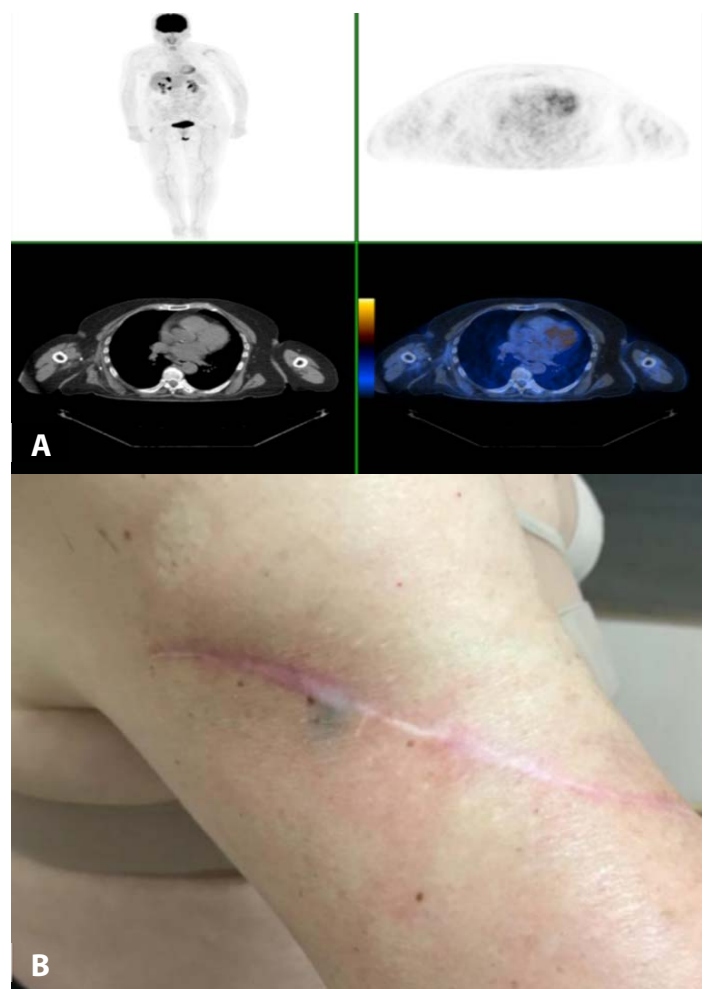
In-transit metastasis and right hilar metastatic lesions on PET/CT.
